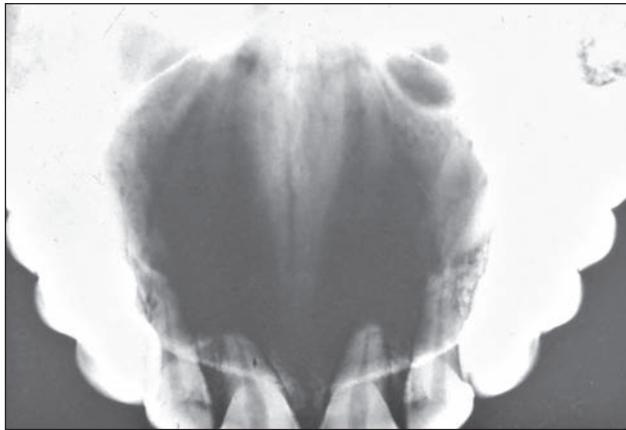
Radiograph of a large nasopalatine duct cyst producing separation of the incisor roots. Lesions like this would, in the past, have been diagnosed as median palatine cysts.
